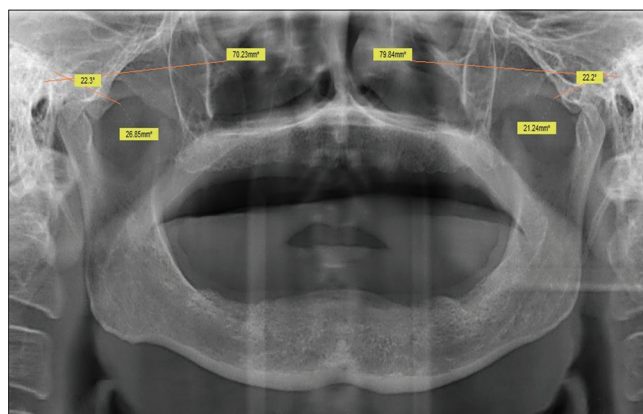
Panoramic radiograph of edentulous patient showing the tracing of the articular eminence inclination
